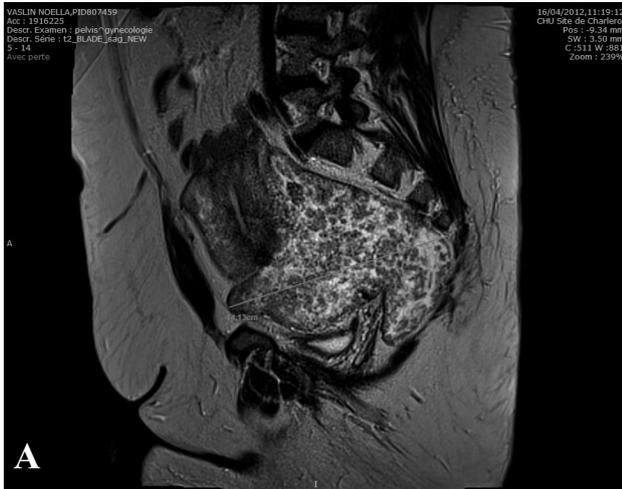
A) Sagittal T2- weighted MR image shows a polylobed mass located in the pelvis. B) Macroscopic anatomopathological picture of R.L. (myxoid degenerating).
